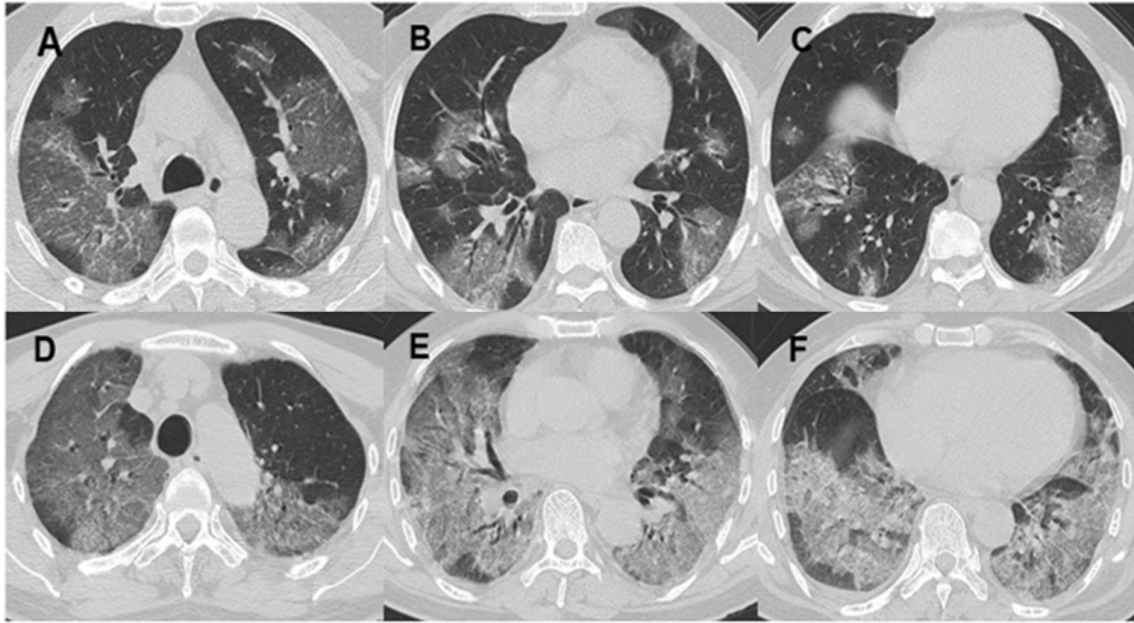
A-C. Non-contrast chest CT images of a 56 year old man with severe COVID-19 pneumonia. CT scans show multiple ground-glass opacities in multiple lung segments, the CT-SS is 28. D-F. Non-contrast chest CT images of a 69 year old man with severe COVID-19 pneumonia. CT scans show multiple ground-glass opacities and septal thickening, the imaging manifestation is the so-called “white lungs”, the CT-SS is 35.
